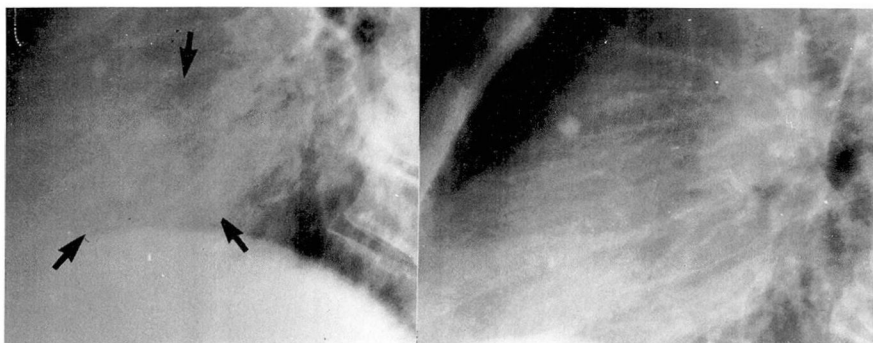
Lateral chest roentgenogram coned down to the lower half of the lung fields showing pre- ^{131}I treated nodules in the lower lung fields on the left and subsequent clearing of such nodules on the chest roentgenogram obtained months later.
